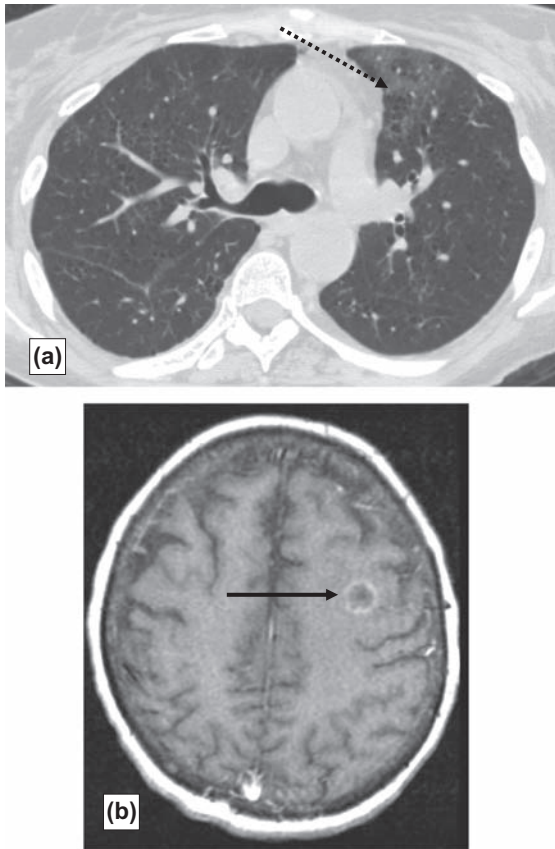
Liver transplant recipient with single colony of *Aspergillus fumigatus* in sputum and low-grade fever. She was otherwise asymptomatic. (a) Chest CT scan reveals patchy infiltrate (arrow). (b) Head CT scan reveals brain abscess (arrow) that was biopsied and grew *Aspergillus* sp. in culture.
